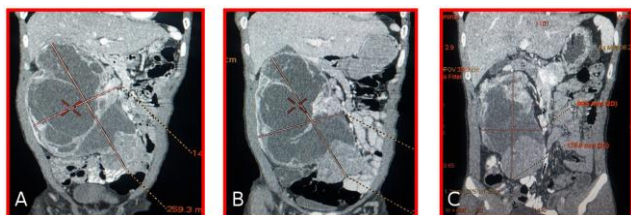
Abdominal CT Scan in coronal plane showed the tumour extent (1A) before RAE was performed, (1B) after 1st RAE performed, (C) after 2nd RAE performed, it shows that a tumour gradually decreased in size according to coronal view
